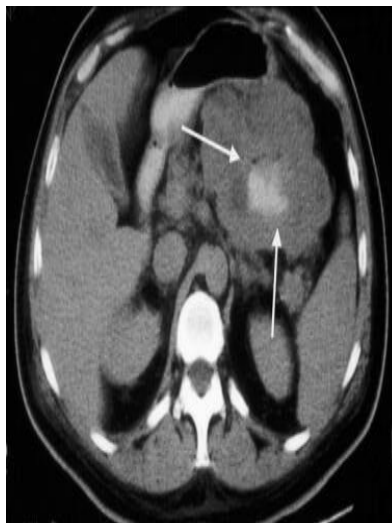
CT scan of abdomen showing a well circumscribed mass of small bowel involving proximal ileum
